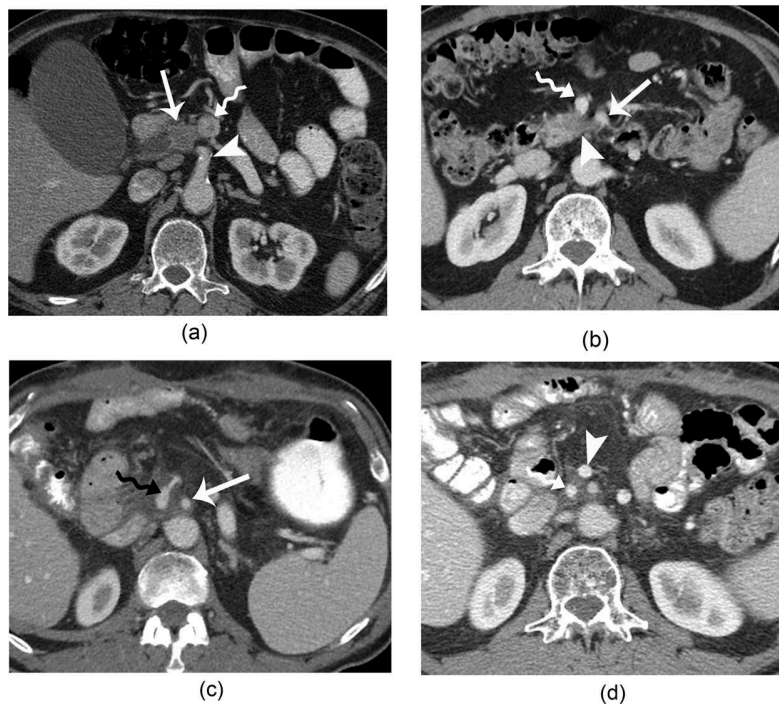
Axial CT scan of the 65 year old female shows (a) a mass in the pancreatic head (arrow) abuts the SMV (squiggly arrow) and is separate from the SMA (arrowhead) as a fat plane is present between the tumor and the SMA (b) Following radiation, however, note that the tumor (arrowhead) has decreased in size, yet now does abut the SMA; in this setting it is difficult to differentiate between fibrotic tissue and involvement of the SMA. The tumor does not encase the SMA and this makes it still resectable. (c) Fluid is present inbetween the SMV (squiggly arrow) and the SMA (arrow), an expected finding after surgery. (d) Six months later the fluid has decreased in amount.
